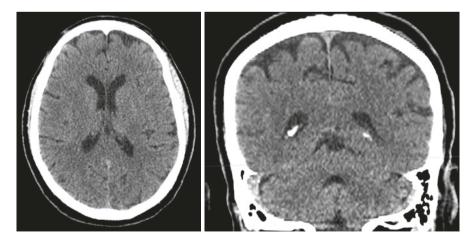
Normal ventricles on CT
